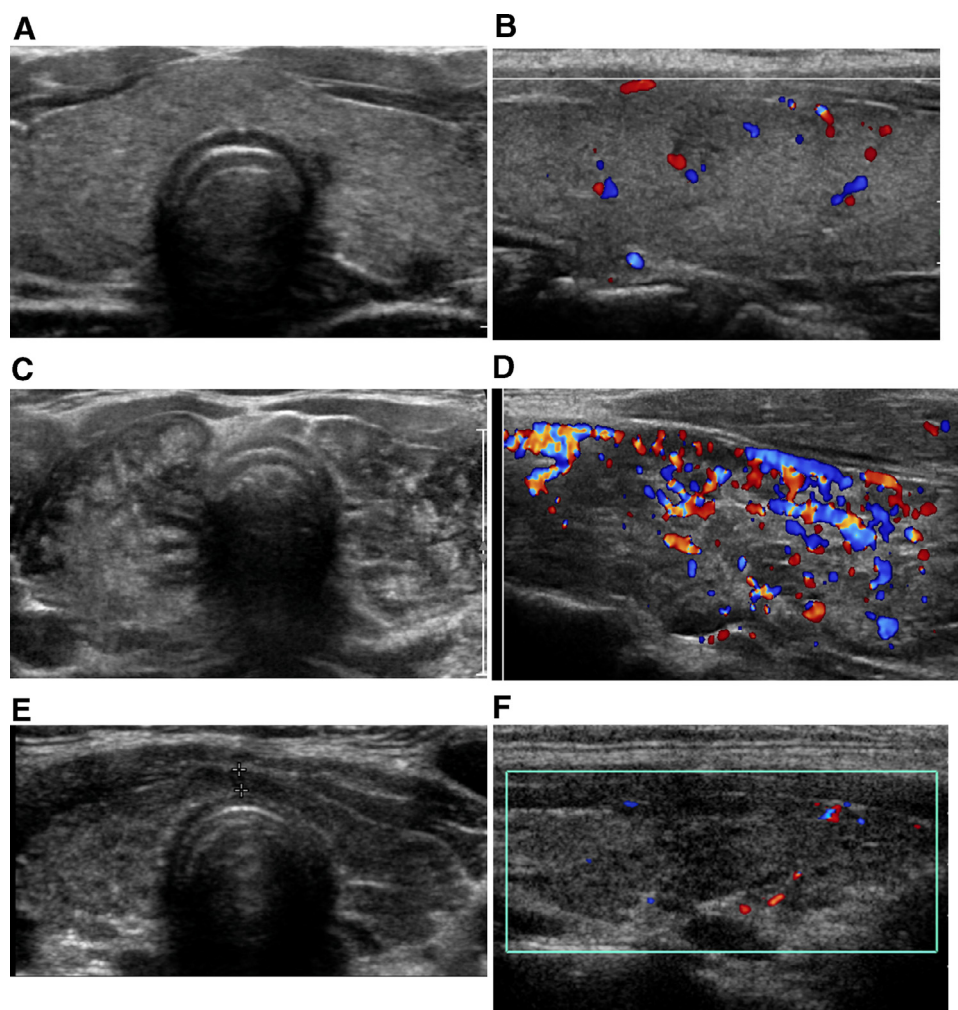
Hashimoto disease. Time progression of imaging findings on gray-scale and color Doppler ultrasound. On initial stages the gland is normal in size or enlarged, retains normal echogenicity but with heterogeneous echotexture (A). Vascularity on color Doppler is normal (B). Subsequently, the echogenicity of the gland becomes heterogeneous (C), and vascularity increases (D). On later stages, the gland atrophies (E) and vascularity is scant (F).
